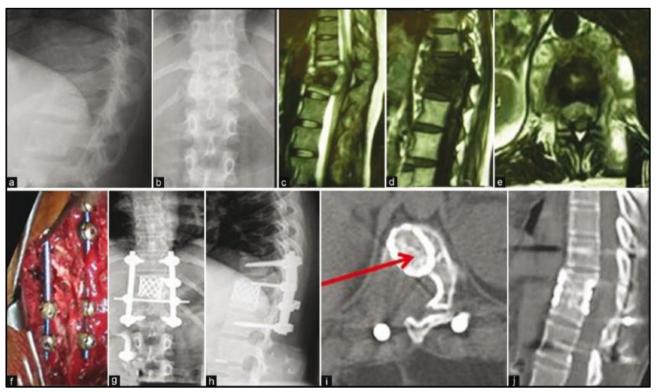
1. Preoperative AP And Lateral X Ray A and B --43 Yr Male with Tb Spine D11/D12 and MRI Shows Active Tb+Abscess + Cord Compression 2. Treated By Posterior Approach 3. Decompression + Pedicular Screw Fixation + Cage 4. Post Op Xray - Decompression + Kyphosis Correction 5. At 11 Month, Bony Fusion on CT Scan
